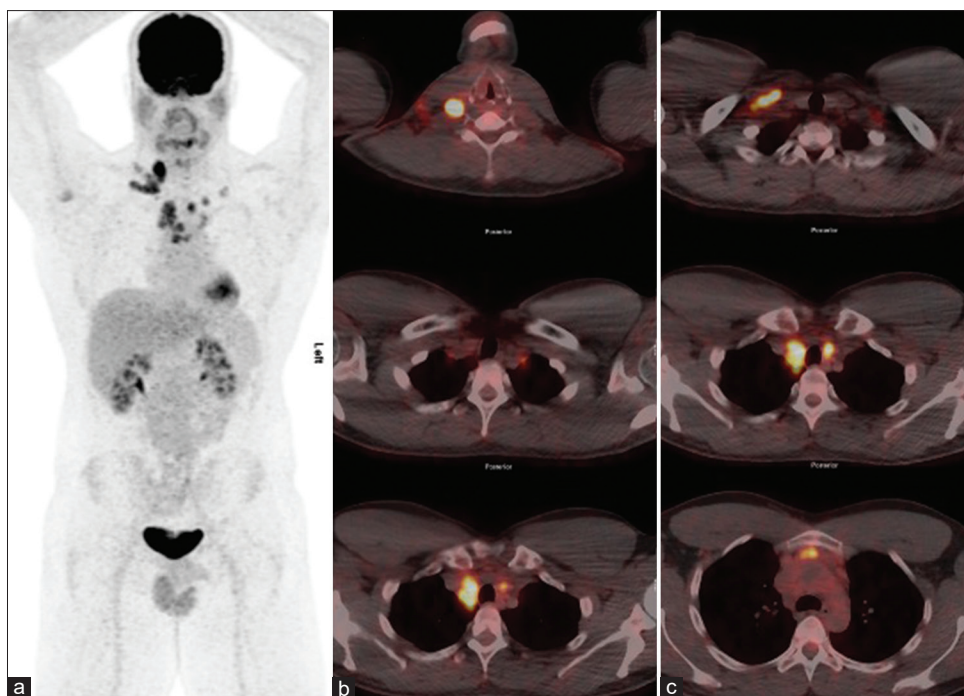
a) Baseline <sup>18</sup>F-FDG PET MIP image and b-c) Transaxial PET/CT images show multiple hypermetabolic lymph nodes at bilateral supraclavicular and anterior mediastinal regions
